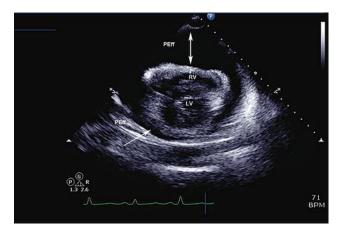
Cardiac tamponade: 2D parasternal short-axis view sweeping scan from base to apex (Video A2) is obtained in the same patient as in Figure A1 with cardiac tamponade. This view is obtained to determine the size and extent of the PEff in each region of the heart during diastole. In this example, the anterior effusion is >4 cm, as denoted by the large double-headed arrow, and the posterior effusion is small (<1 cm). Of note, the patient position should be noted when determining the size and location of the effusion, because it may vary with free-flowing effusions.
